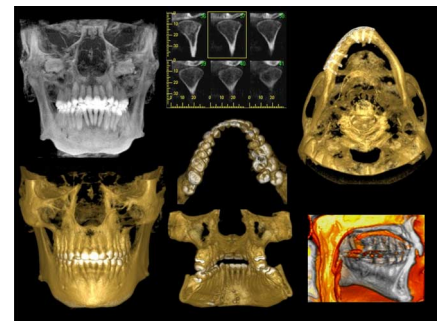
Representative three-dimensional cone-beam computed tomography (CBCT) reconstructions, each possible from a single low-dose 20-second imaging sequence. Multiple different reconstructions are possible with one exposure.
